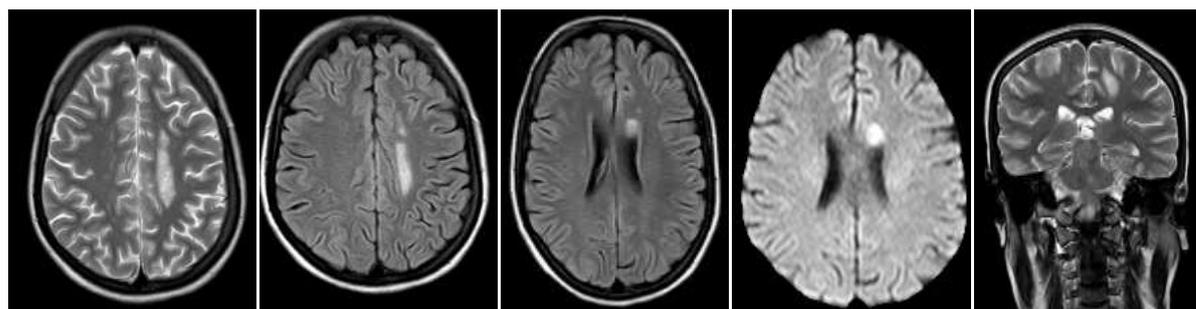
2 MRI scan of brain showing multifocal round to oval areas of altered signal in bilateral Centrum semiovale, left periventricular deep white matter and left anterior pericallosal area.
